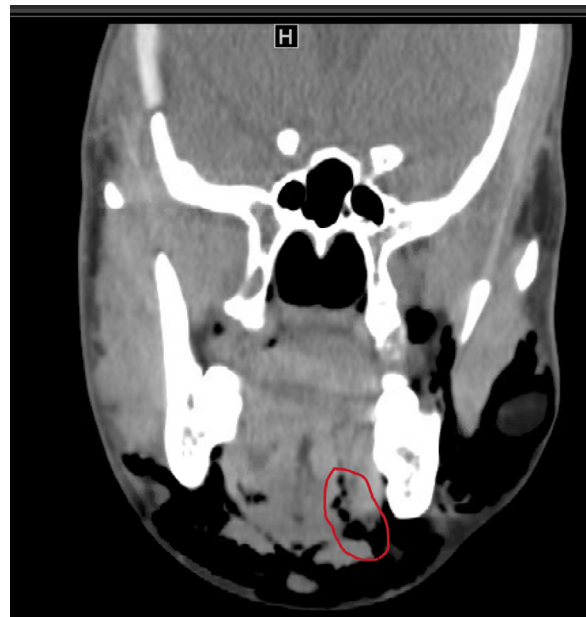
Coronal view of a computed tomography (CT) neck scan without contrast at the level of the mandibular ramus. There is prominent air emphysema in the left masticator, buccal, and bilateral submandibular spaces with a boutonniere defect of the left mylohyoid (red).
